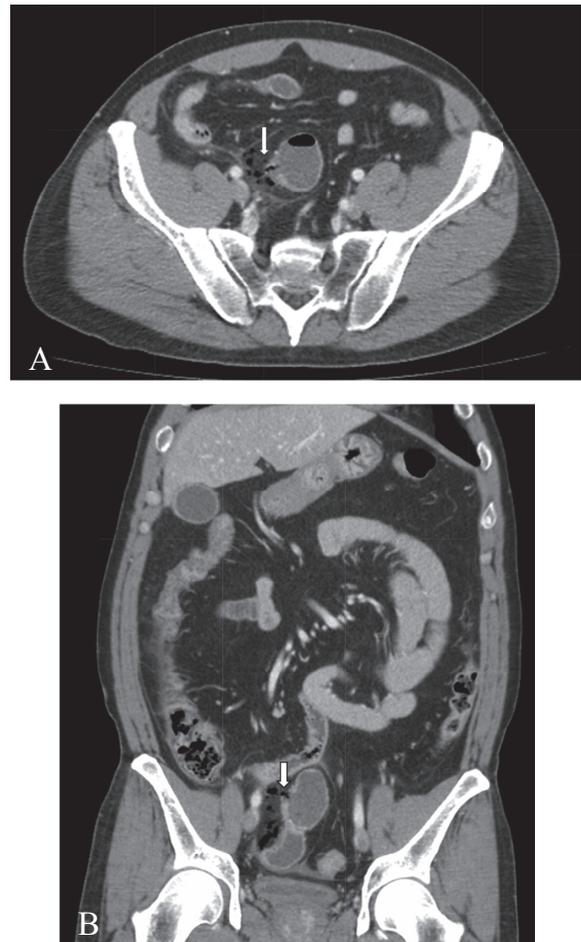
Intravenous contrast-enhanced computed tomography of the abdomen showed an outpouching, blind-ending, fluid-filled structure in continuity with the distal ileum, which depicted wall perforation (arrow in A and B) and extraluminal air bubbles.
